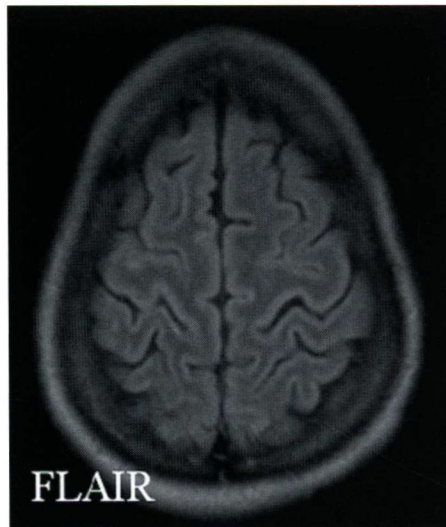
A less common pattern of global anoxic injury. Axial FLAIR and DWI images show preferential involvement of the deep gray matter with preservation of the cortex except in the perirolandic area.
